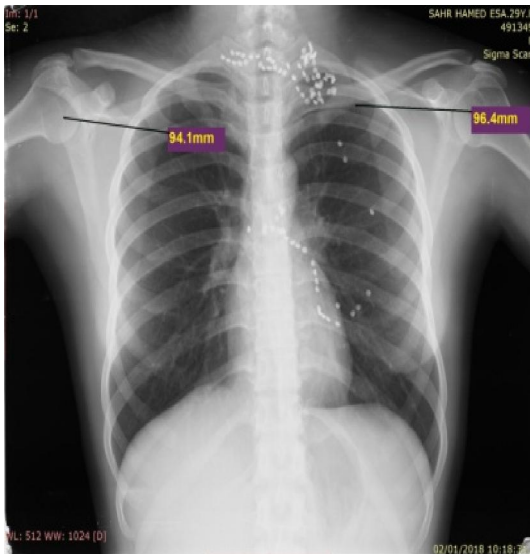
A photograph of plain x-ray of the chest of the previous person showing the parameters of the scapula measured from the anteroposterior roentgenograms of the chest. On left side, Maximum Scapular Width (MSW) is 96.4mm. on the right side Maximum Scapular Width (MSW) is 94.1mm
